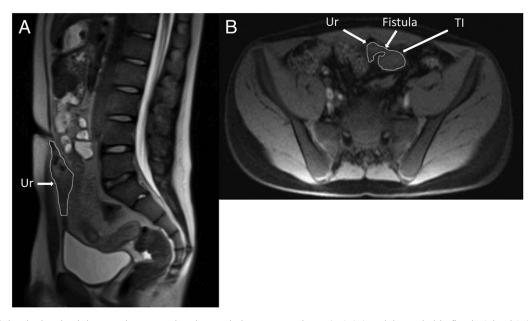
An abdominal and pelvic MRI demonstrating the urachal remnant and cyst (Ur) (A) and the probable fistula (Fistula) (B) leading from the ileum (TI) to the urachal cyst (Ur).
